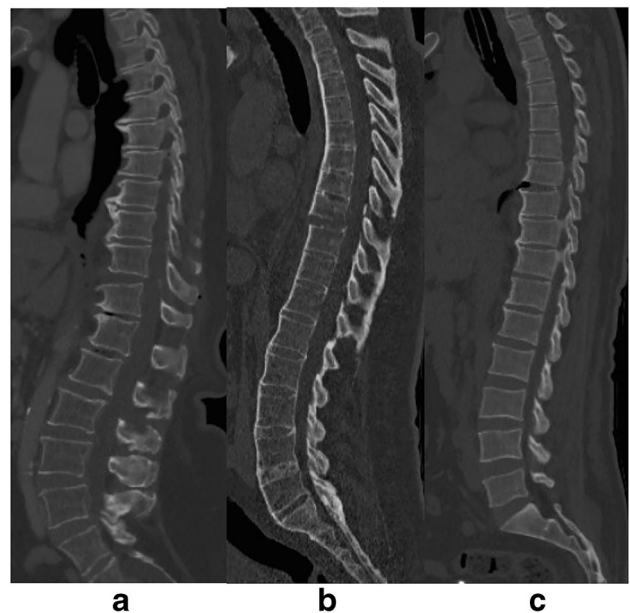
Sagittal CT image of the spine with type B3 fractures in NAS (A), AS (B), and DISH (C). CT, computed tomography; NAS, non-ankylosed spines; AS, ankylosing spondylitis; DISH, diffuse idiopathic skeletal hyperostosis
